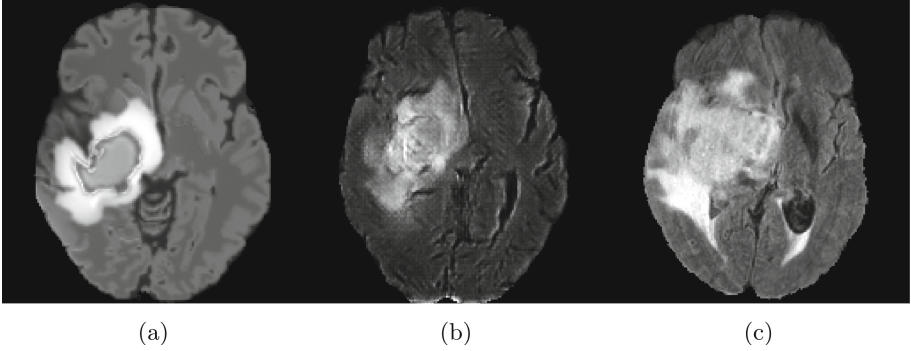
Domain adaptation results: (a) represents a synthetic FLAIR brain image, (b) represents the domain adapted synthetic FLAIR image, (c) represents the real BraTS FLAIR image. As we can see from the intensity distributions, the values in the adapted images are qualitatively closer to the real images.
